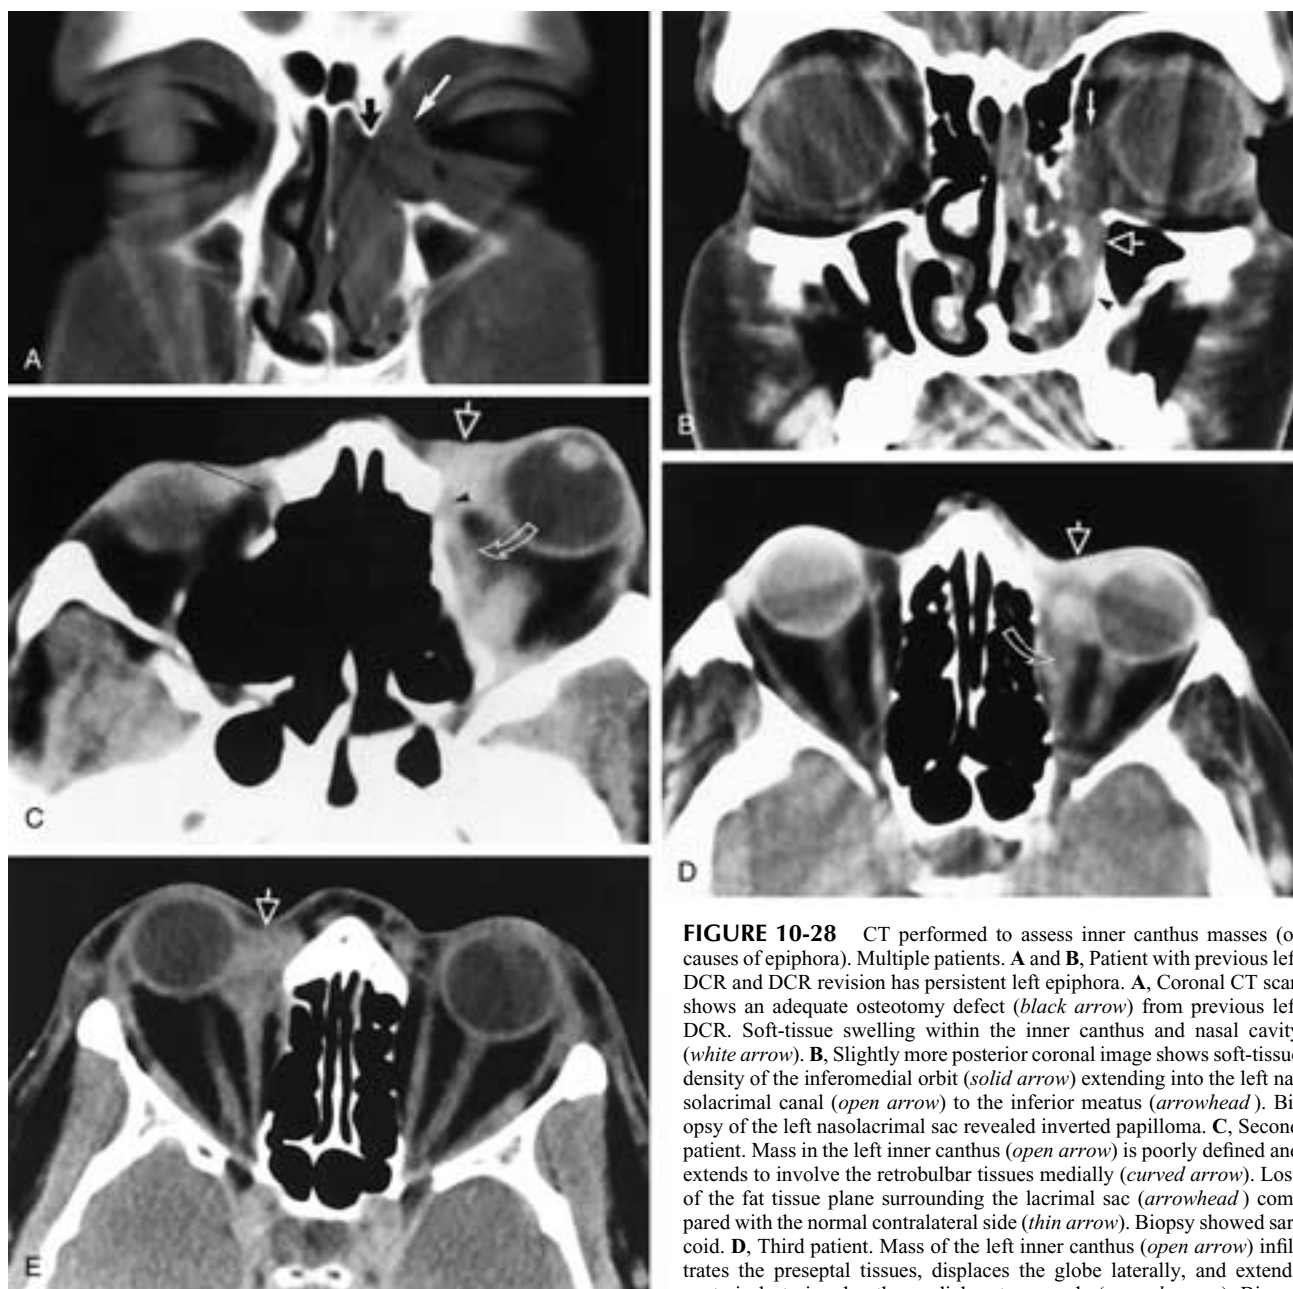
CT performed to assess inner canthus masses (or causes of epiphora). Multiple patients. A and B, Patient with previous left DCR and DCR revision has persistent left epiphora. A, Coronal CT scan shows an adequate osteotomy defect (*black arrow*) from previous left DCR. Soft-tissue swelling within the inner canthus and nasal cavity (*white arrow*). B, Slightly more posterior coronal image shows soft-tissue density of the inferomedial orbit (*solid arrow*) extending into the left nasolacrimal canal (*open arrow*) to the inferior meatus (*arrowhead*). Biopsy of the left nasolacrimal sac revealed inverted papilloma. C, Second patient. Mass in the left inner canthus (*open arrow*) is poorly defined and extends to involve the retrobulbar tissues medially (*curved arrow*). Loss of the fat tissue plane surrounding the lacrimal sac (*arrowhead*) compared with the normal contralateral side (*thin arrow*). Biopsy showed sarcoma. D, Third patient. Mass of the left inner canthus (*open arrow*) infiltrates the preseptal tissues, displaces the globe laterally, and extends posteriorly to involve the medial rectus muscle (*curved arrow*). Biopsy revealed basal cell carcinoma. E, Fourth patient. Mass of the right inner canthus (*arrow*) obscures insertion of the medial rectus into the globe. Biopsy found orbital pseudotumor. (See also [Fig. 10-20](#).)
